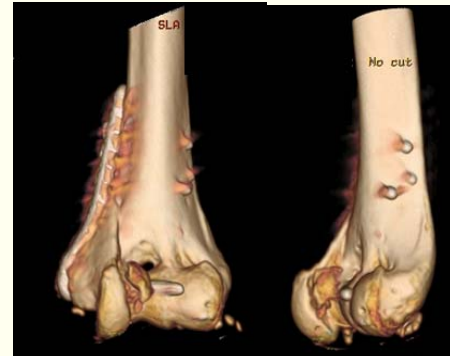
Post-operative x-ray after corrective osteotomy and fixation.
